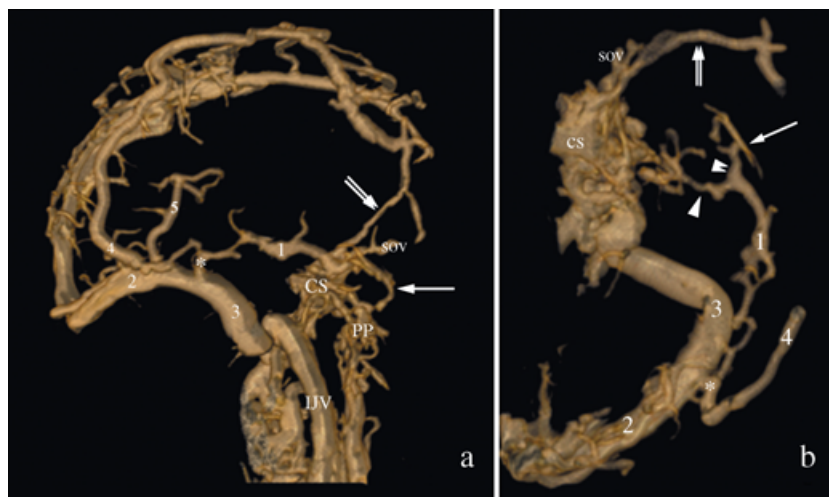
Three-dimensional images after CT reconstruction of a corrosion cast of the cranial venous system on a Vitrea workstation (Vital Images, Minnesota, USA) (0.8-mm slices, every 0.4 mm; Philips MX 8000 IDT 16-channel multirow detector, Philips Medical Systems, Best, The Netherlands). The cortical veins have been virtually dissected. (a) Right lateral view showing a petrosquamosal sinus (PSS): (1), the transverse sinus; (2) the sigmoid sinus; (3) the cavernous sinus (CS), a temporoparietal diploic vein; (4) the internal jugular vein (IJV), the pterygoid plexus (PP), and the superior ophthalmic vein (sov). The PSS is connected to the transverse sinus/sigmoid sinus junction (asterisk). Close to this point, the PSS receives a posterior temporoparietal diploic vein. The single arrow points to a deep temporal vein. The double arrow represents the sphenoparietal sinus, which drained a large anterior parietal diploic vein into the cavernous sinus. (b) Superior view of the right middle cranial fossa. Details as in (a). The connection of the PSS with the emissary veins of the middle cranial fossa (foramen ovale) is marked by an arrowhead. The double arrowhead indicates the connection with the deep temporal vein through the postglenoid foramen (PGF). The sphenoparietal sinus (double arrow) courses over the superior ophthalmic vein (sov) and joins the anterior superior aspect of the cavernous sinus (CS).
